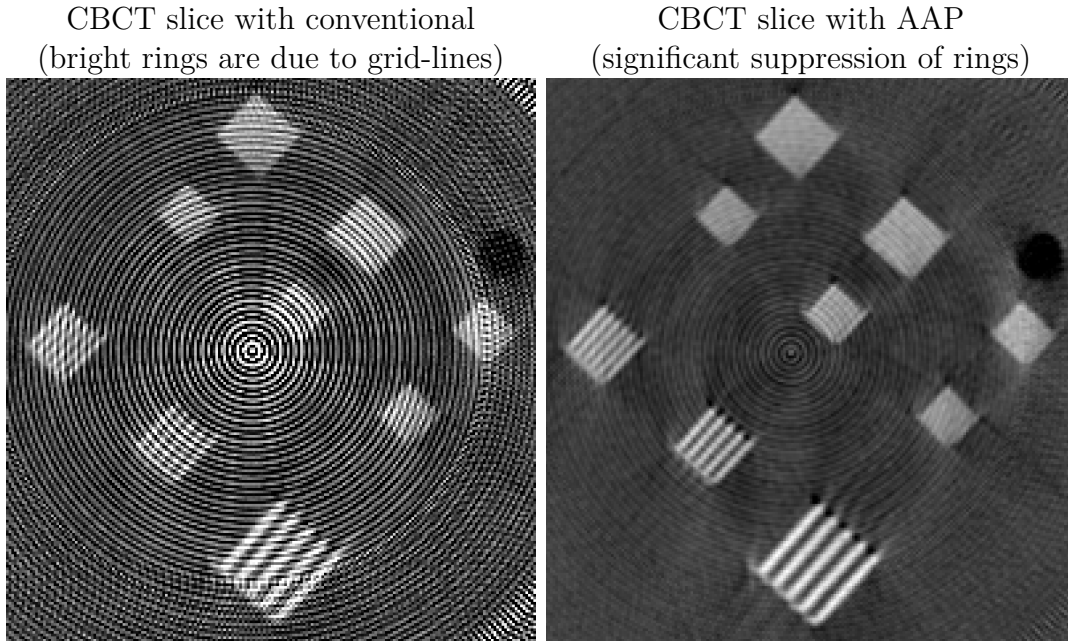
A cone-beam CT reconstructed slice with conventional projections (left, binned 4×4) and AAP projections (right, $4 \times$ pixel size) showing resolution bar-patterns. The CT slice with conventional projections has ring artifacts caused by the grid artifact, which are suppressed with the AAP approach.
